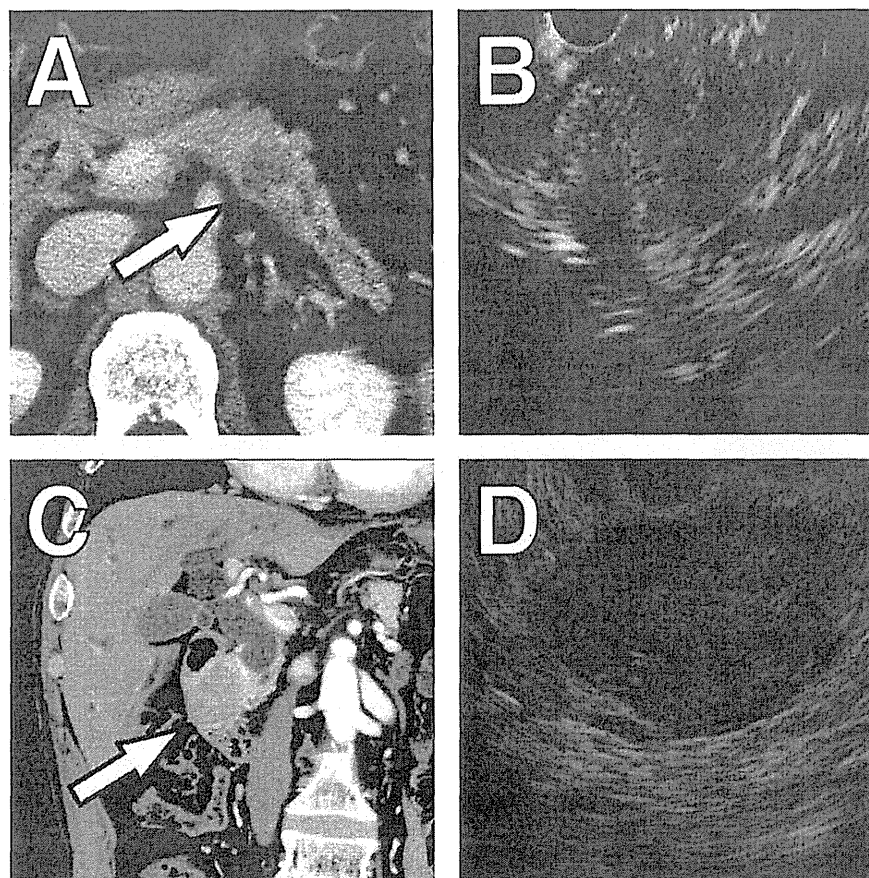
Representative images of control cases. Pancreatic ductal adenocarcinoma. (A) Contrast-enhanced CT showed a hypodense tumor in the body of the pancreas with pancreatic duct dilatation (white arrow), and (B) EUS showed a mixed-echoic mass with an irregular border. Pancreatic neuroendocrine tumor. (C) Contrast-enhanced CT showed a hyperdense tumor in the head of the pancreas (white arrow), and (D) EUS showed a well-circumscribed hypoechoic mass.
